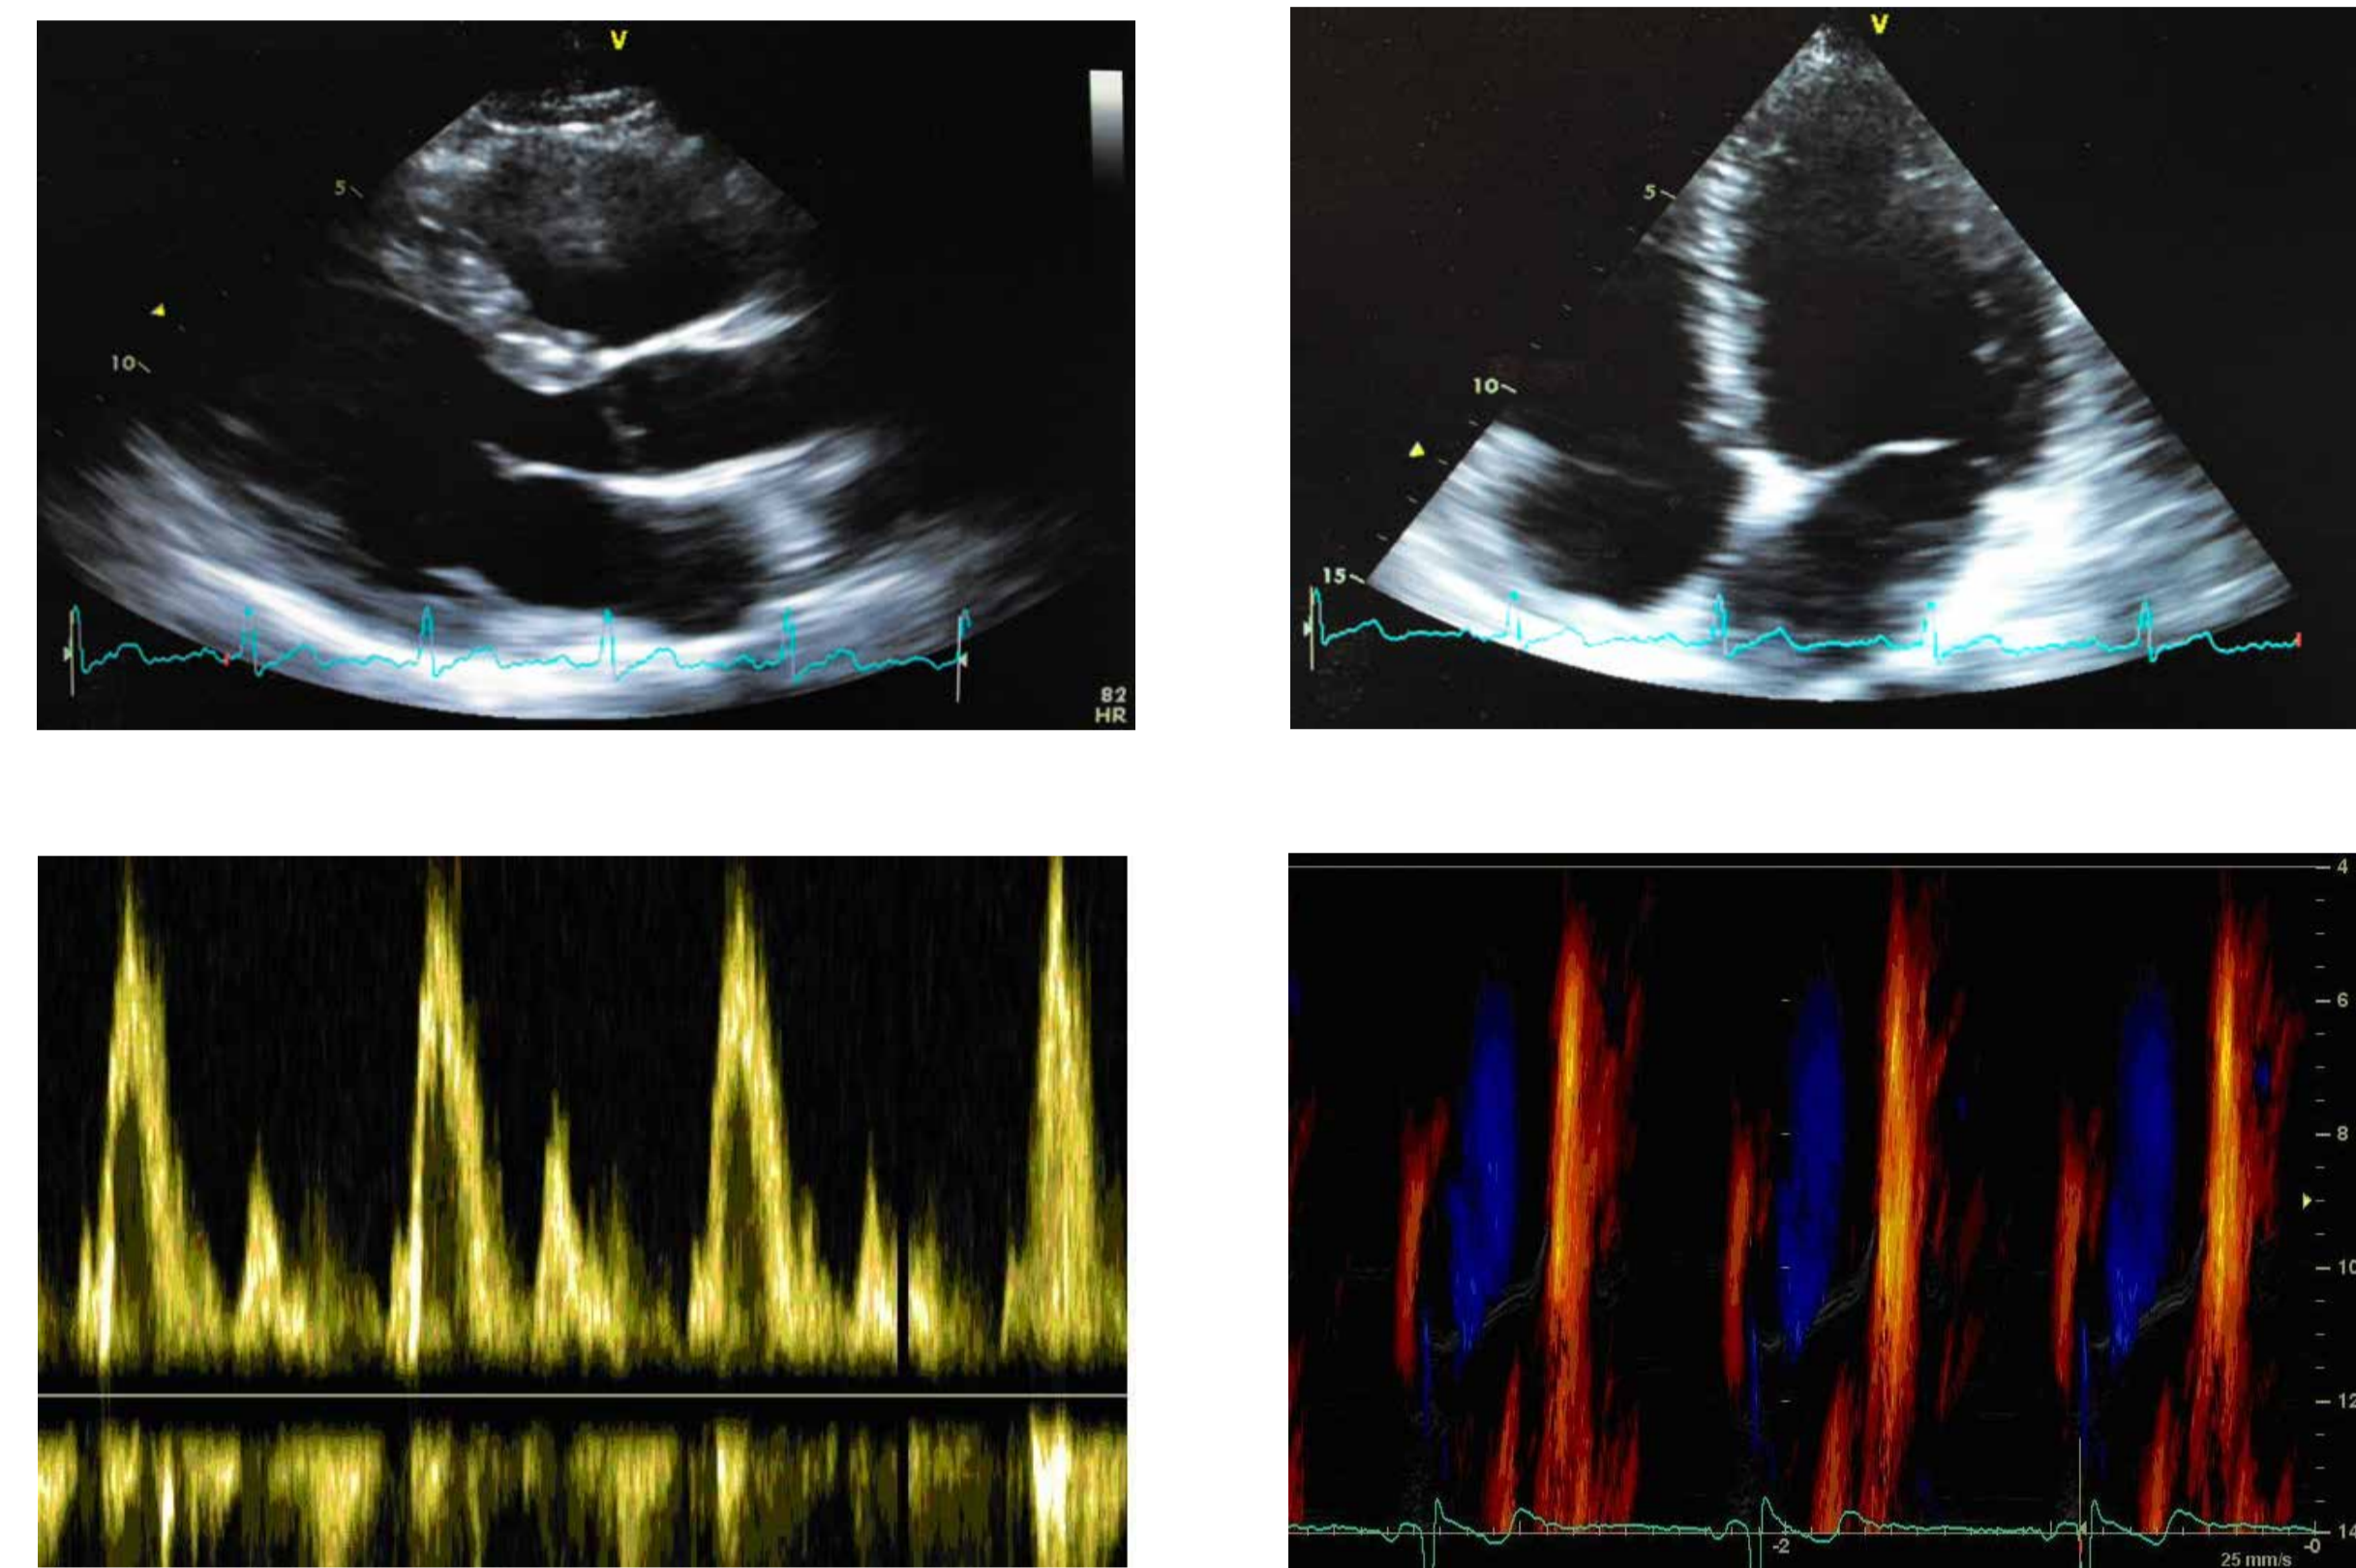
Here we report for the first time the use of transthoracic echocardiology to examine the heart of FES-trained subjects with tetraplegia and paraplegia. Two-dimensional (2D) parasternal view (top left), apical 4-chamber view (top right), early and late left ventricular filling (bottom left) and left ventricular flow propagation velocity (bottom right) of an expert FES-rower.
